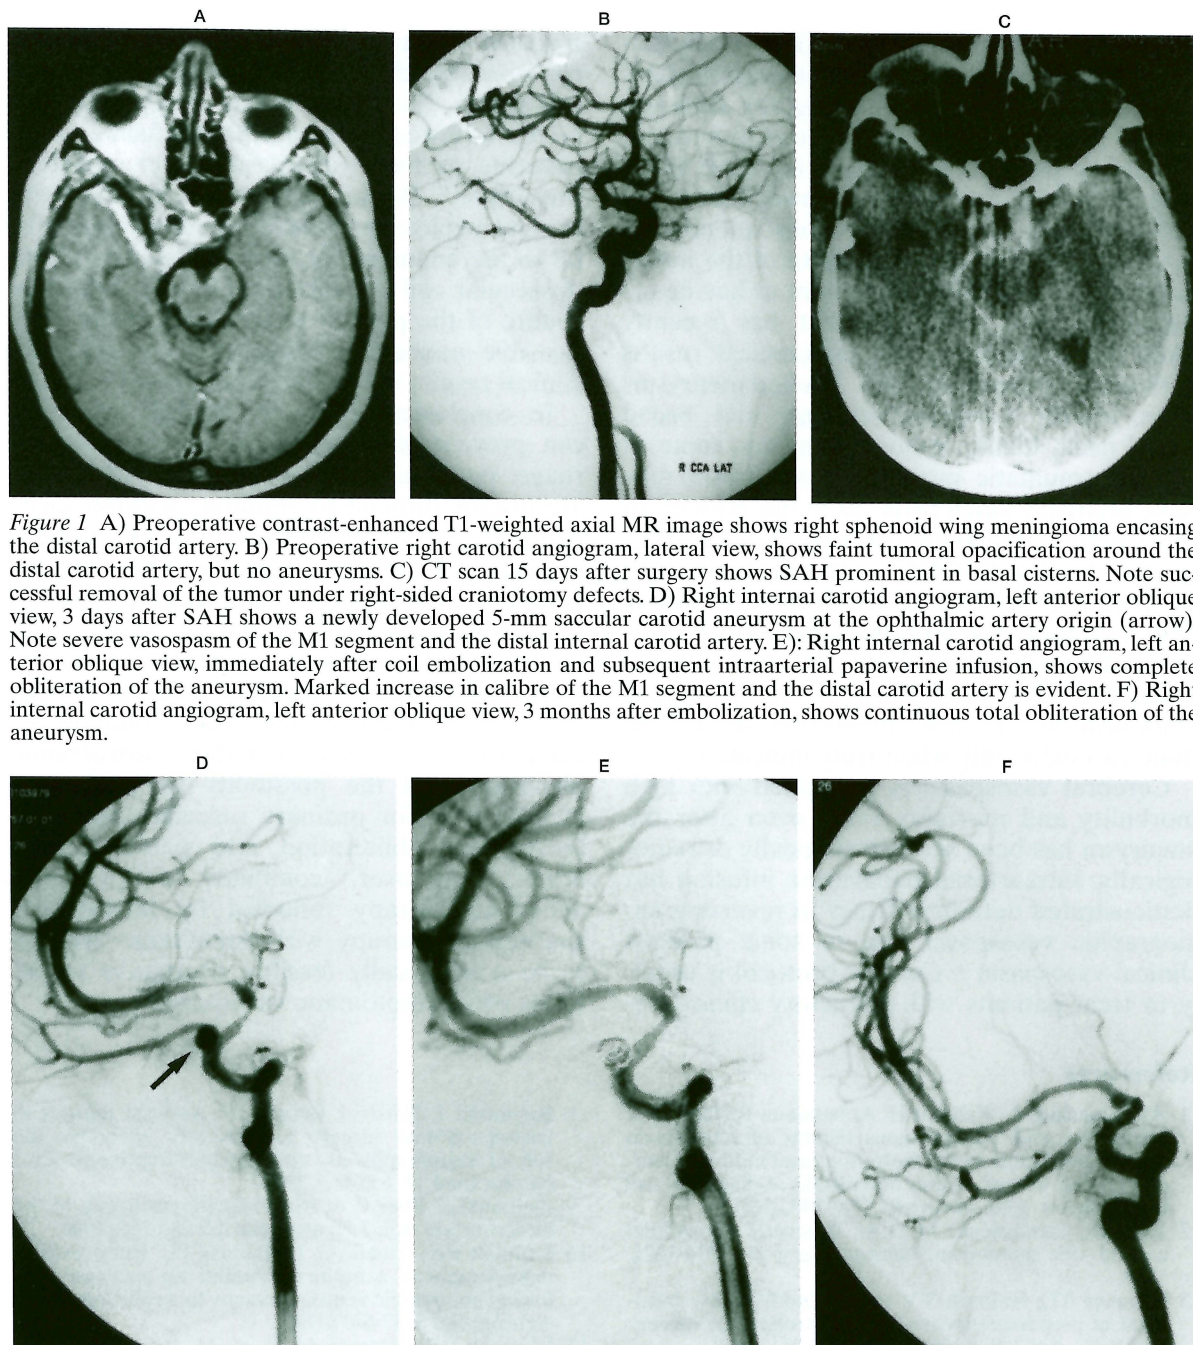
A) Preoperative contrast-enhanced T1-weighted axial MR image shows right sphenoid wing meningioma encasing the distal carotid artery. B) Preoperative right carotid angiogram, lateral view, shows faint tumoral opacification around the distal carotid artery, but no aneurysms. C) CT scan 15 days after surgery shows SAH prominent in basal cisterns. Note successful removal of the tumor under right-sided craniotomy defects. D) Right internal carotid angiogram, left anterior oblique view, 3 days after SAH shows a newly developed 5-mm saccular carotid aneurysm at the ophthalmic artery origin (arrow). Note severe vasospasm of the M1 segment and the distal internal carotid artery. E) Right internal carotid angiogram, left anterior oblique view, immediately after coil embolization and subsequent intraarterial papaverine infusion, shows complete obliteration of the aneurysm. Marked increase in calibre of the M1 segment and the distal carotid artery is evident. F) Right internal carotid angiogram, left anterior oblique view, 3 months after embolization, shows continuous total obliteration of the aneurysm.
